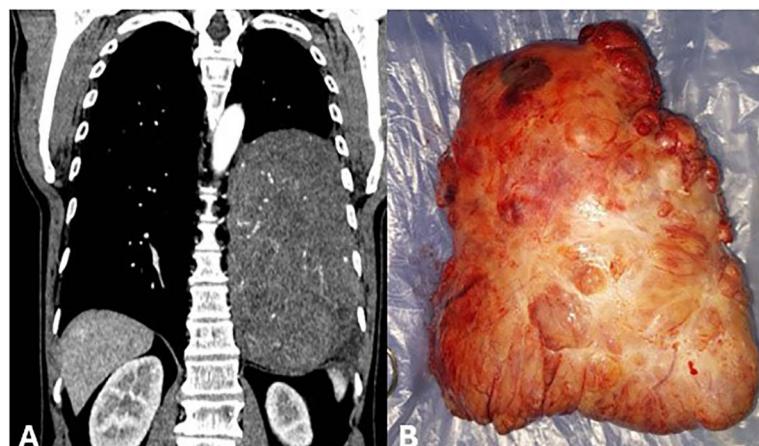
A. Contrast-enhanced chest computed tomography shows an expansive lesion in the lower lobe of the left lung, in close contact with the pleura, with marked vascularization following contrast administration. B. Firm pleural tumor with a fibrous appearance, weighing approximately 1800 mg.
